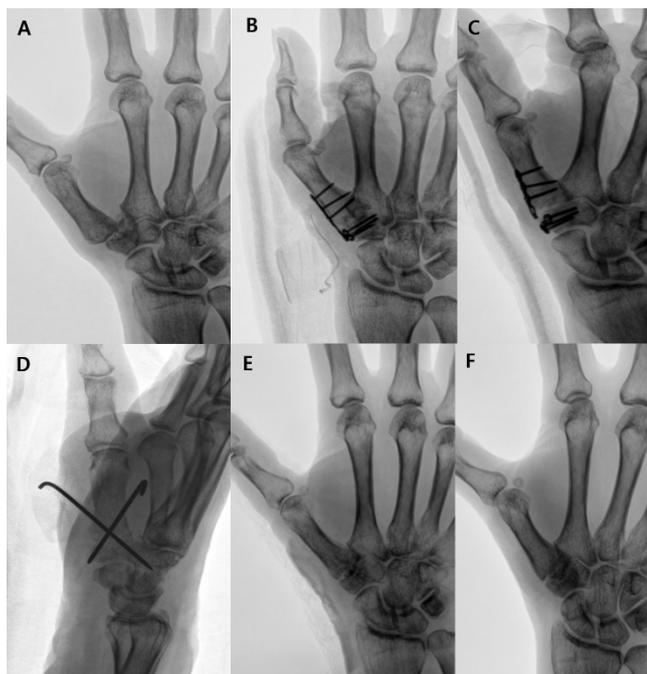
A 55-year-old female patient with symptomatic thumb carpometacarpal (CMC) osteoarthritis of the right thumb. (A) Preoperative posteroanterior (PA) radiograph of the thumb demonstrates CMC osteoarthritis. (B) Immediate postoperative radiograph demonstrates arthrodesis with T-plate fixation using a 1.5-mm plate. © At 2 weeks postoperatively, radiograph demonstrates implant failure with plate breakage. (D) Radiograph after revision arthrodesis demonstrates removal of the plate and fixation with 1.6-mm K-wires. (E,F) At 6 months postoperatively, radiograph demonstrates complete bone union, and the patient reported improved pain and function.
